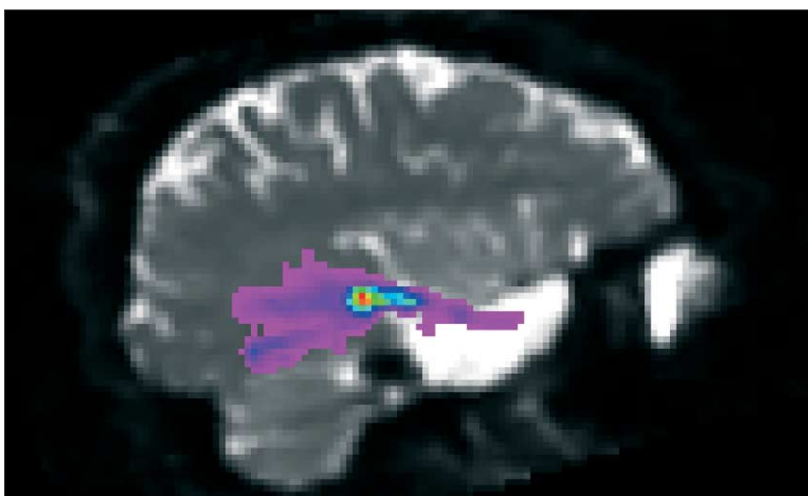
Tractography outlining the right optic radiation, superimposed on a sagittal MRI scan after right anterior temporal lobe resection
